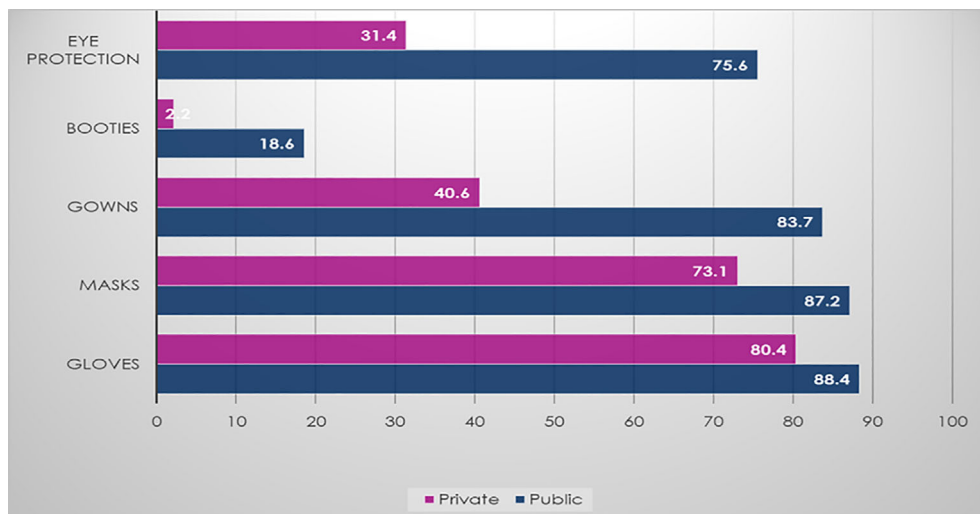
Percentage access public hospital versus private practice sonographers to different types of protective equipment (Total number of sonographers in private practice = 228, total number of sonographers in public hospitals = 76)
